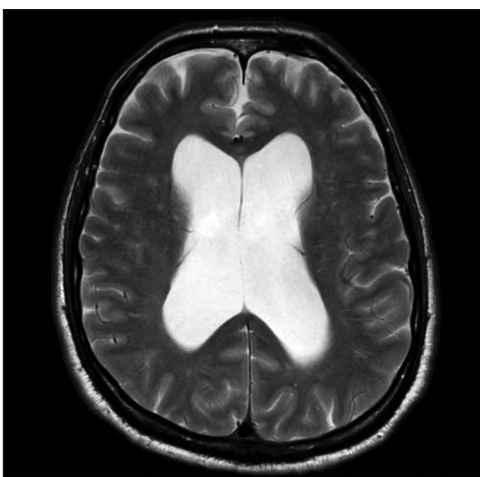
Preoperative MRI: Ventriculomegaly with minimal periventricular lucency.
